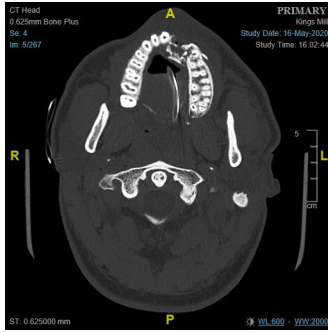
CT imaging showing the maxillofacial injury.
